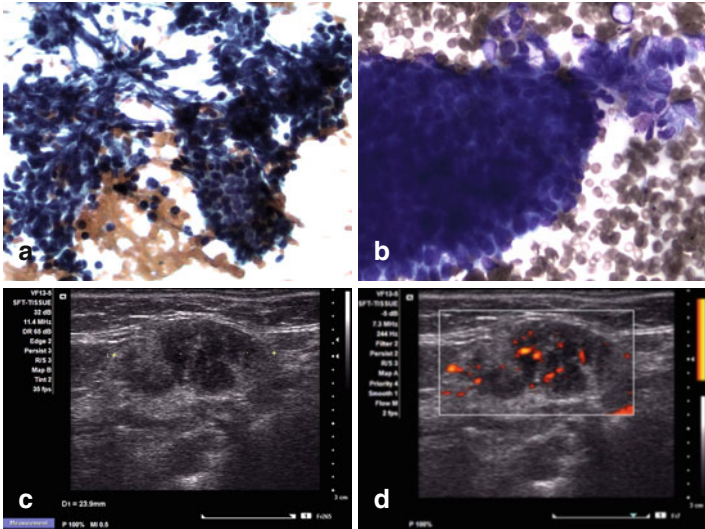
Chronic sialadenitis. Chronic inflammatory cells, predominantly entangled with benign salivary gland elements (a) and reactive aggregates of ductal cells with squamous metaplasia (b). Ultrasound shows a complex heterogeneous mass with anechoic foci, septae of slightly hyperechoic bands, and mild internal blood flow by Doppler examination (c, d)
